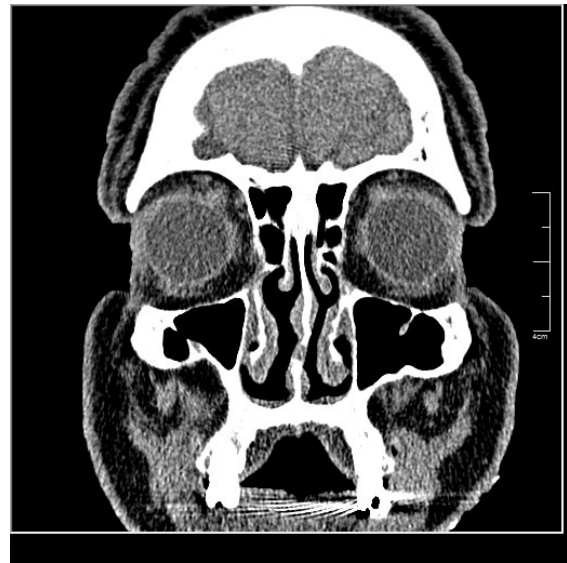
CT scan of sinonasal region, Soft tissue window, showed bilateral patent nasal cavity 4 year after MAST.
